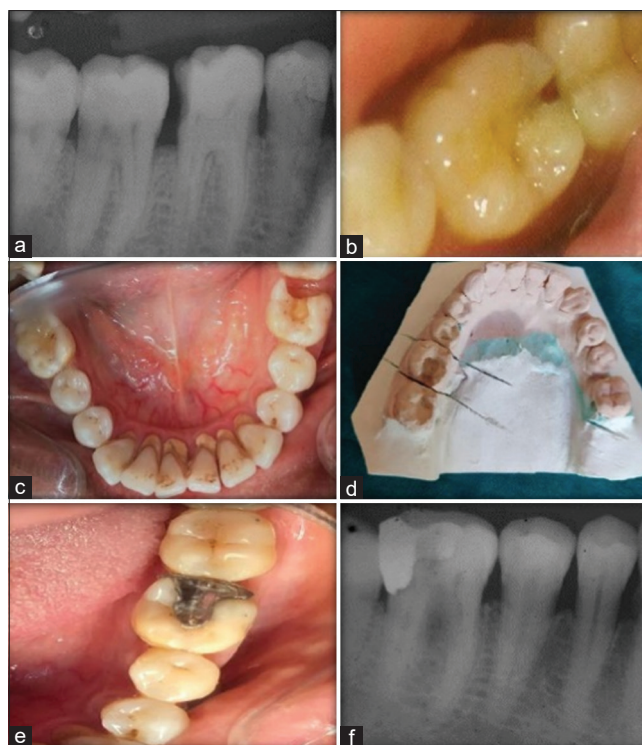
(a) Pre-operative radiograph (b) pre-operative picture (c) cavity preparation (d) cast (e) post-operative picture (f) post-operative radiograph
